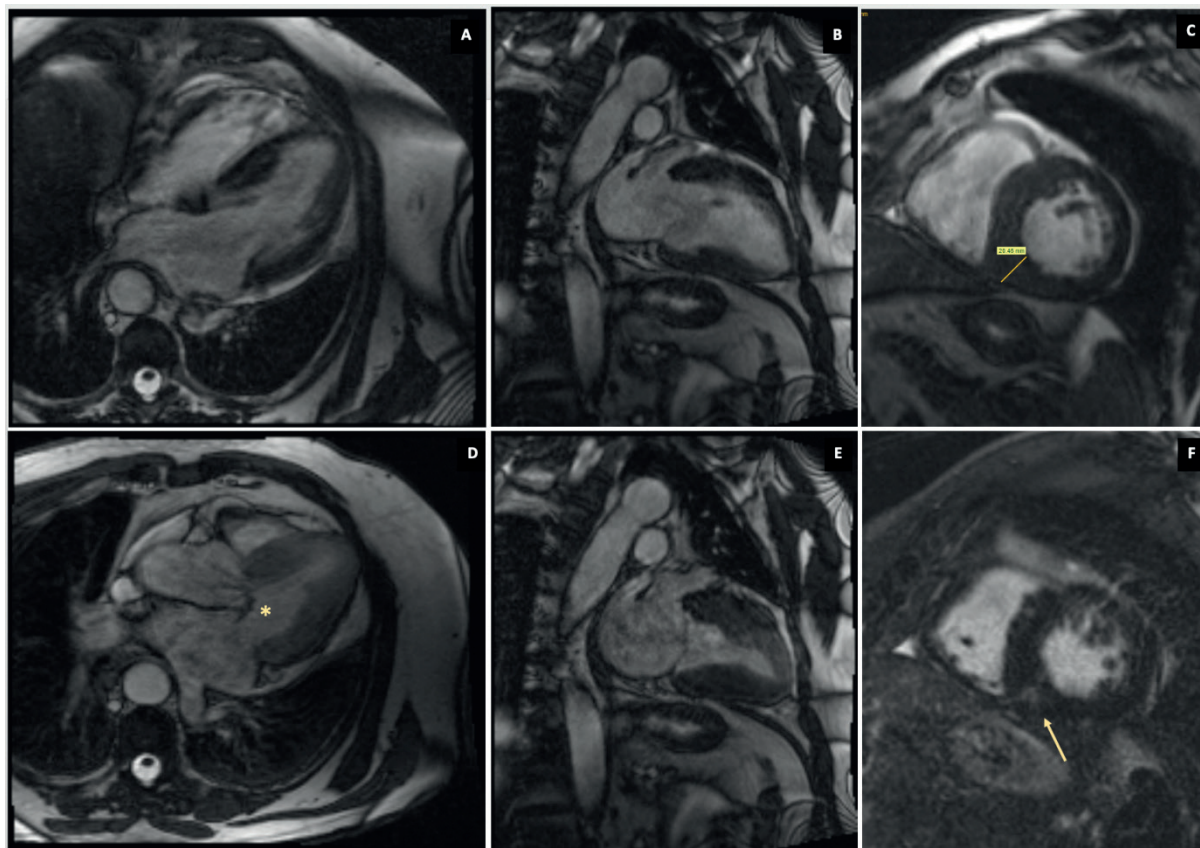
A, B, C, E) Magnetic Resonance Imaging evaluation showing asymmetrical left ventricular hypertrophy, with maximal thickness of 20 mm in the inferoseptal wall (C); D) 3-Chamber view depicting systolic anterior motion of the mitral valve leaflet (*); F) Mid-ventricular short-axis view revealing the presence of intramyocardial late gadolinium enhancement located in the inferoseptal mid wall (→), suggestive of myocardial fibrosis.
